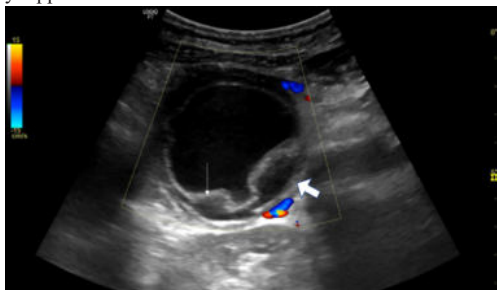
Colour doppler ultrasound image showing a thick walled
